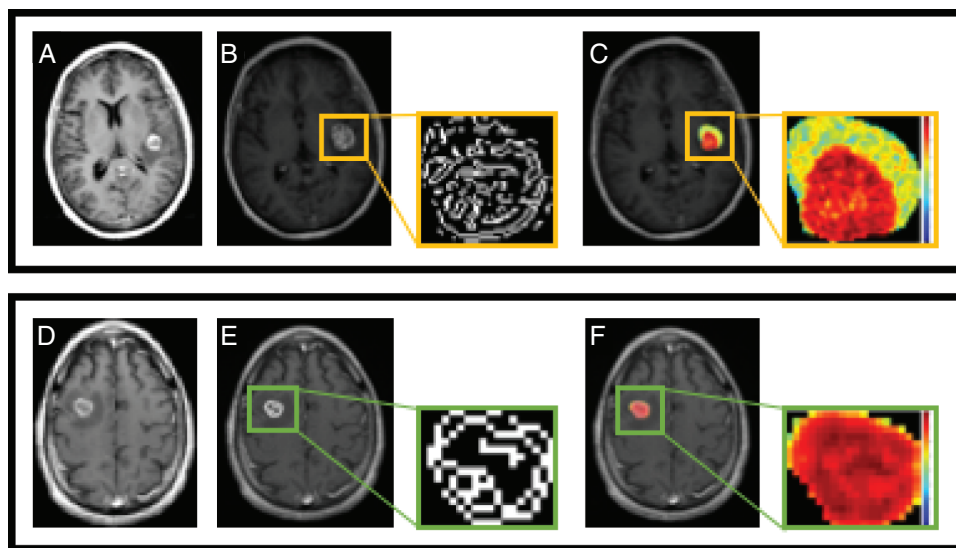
MR images of a 56-year-old female patient with a left frontotemporal lobe melanoma brain metastasis that did not respond to ipilimumab and required unplanned radiation (upper panel), and a 75-year-old male patient with a right frontal lobe melanoma brain metastasis that had a complete response to ipilimumab (lower panel). Pretreatment post-contrast imaging is shown in (A) and (D) for each patient, respectively. Edge-filtered images for each metastatic lesion show that the LoG edges are more complex in the metastasis that progressed (B) compared with the metastasis that responded (E). Additionally, a representation of the extracted entropy feature shows there is higher entropy, highlighted by the increase in variation as well as disorder in the gray level distribution, in the progressing metastatic lesion (C) in comparison with the responding metastatic lesion (F).
